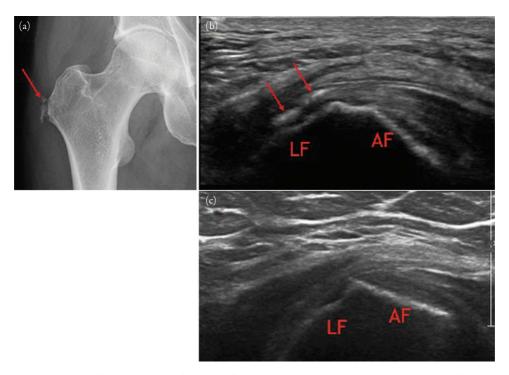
Hip calcific tendinosis. After the rotator cuff tendons of the shoulder, the second most common location for symptomatic hydroxyapatite deposition disease (HADD) is the gluteus tendon insertions at the greater trochanter. Irregular foci of calcification (arrow) project over the soft tissues near the right greater trochanter on this AP hip radiograph (Panel (a)). The transverse grayscale sonographic image (Panel (b)) of the lateral hip region shows 2 echogenic foci (arrows) near the lateral facet (LF) of the greater trochanter. This is the site of insertion of the gluteus medius tendon. The gluteus minimus tendon inserts on the anterior facet (AF). The transverse grayscale sonographic image (Panel (c)) of the asymptomatic contralateral greater trochanter in this patient shows no calcific deposits in the region of the greater trochanteric gluteus tendon insertions.
